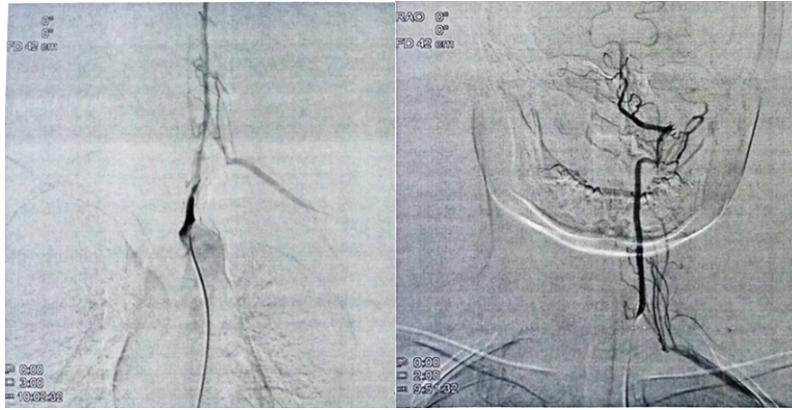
Multi-slice computed tomography (MSCT) angiography. Results show occlusion of the left proximal inner carotid artery after branching at the aortic arch, and occlusion of the left subclavian artery.
